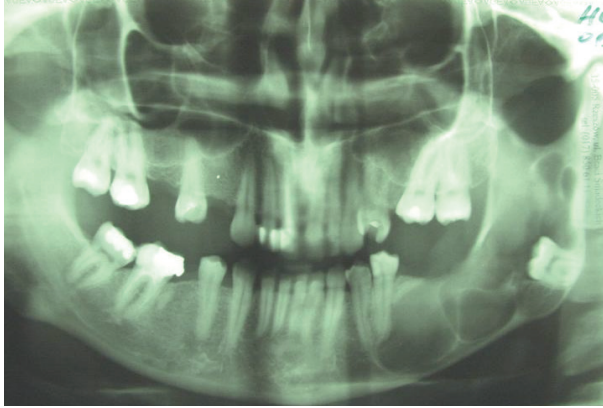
Orthopantomogram, condition at the patient's admission to the facility
